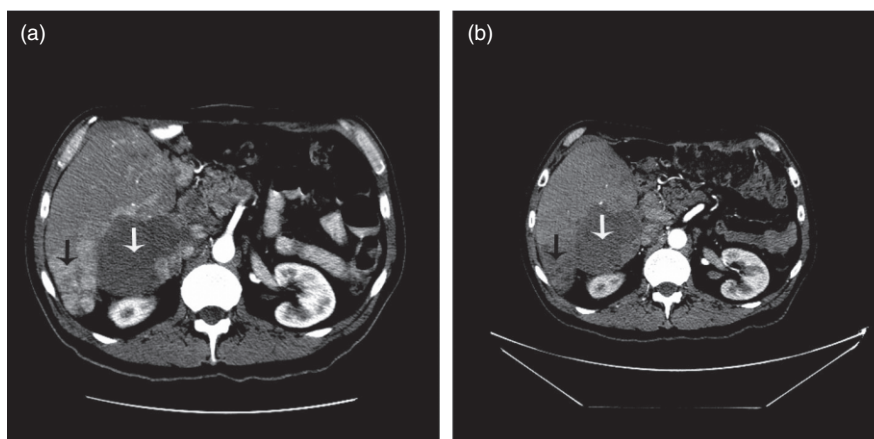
Therasphere therapy after surgical intervention. (a) An abdominal computed tomography (CT) scan showing a previously-treated neuroendocrine tumour (NET) metastatic lesion with radiofrequency ablation (RFA) in segment VII (white arrow) with no enhancement. However, multiple enhancing metastatic nodules (black arrow) are present adjacent to the ablated segment. (b) CT scan images of the same patient 3 months after ^{90}Y therapy of the right lobe of the liver showing a complete response. The vascular enhancement has virtually disappeared, but the lesions themselves are persistent
